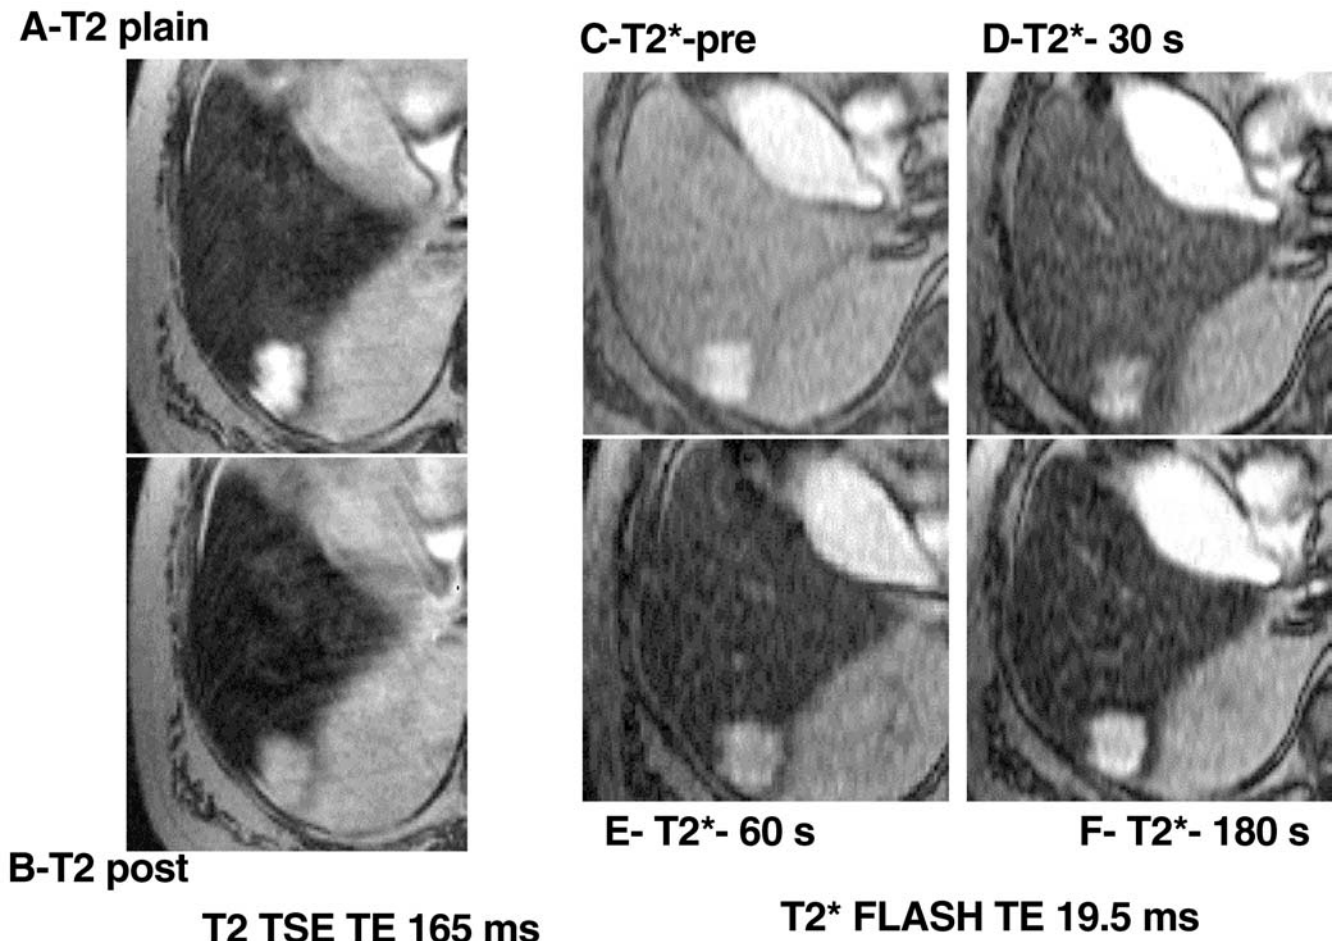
Hemangioma: dynamic T2* and accumulation-phase MRI. T2-weighted TSE images (a plain and b post) show decreased signal on enhanced images because of pooling of contrast material within the lesion. Dynamic ferucarbotran-enhanced T2*-weighted FLASH images (c pre, d 30 s, e 60 s, and f 180 s) show dynamic changes in tumor and liver enhancement due to a shortened T2-relaxation time during the perfusion phase with peripheral-nodular enhancement within the hemangioma
